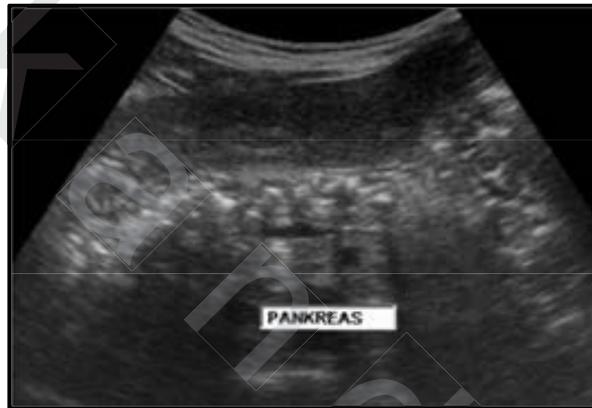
Ultrasound image of patient with chronic pancreatitis.⁽³²⁾
